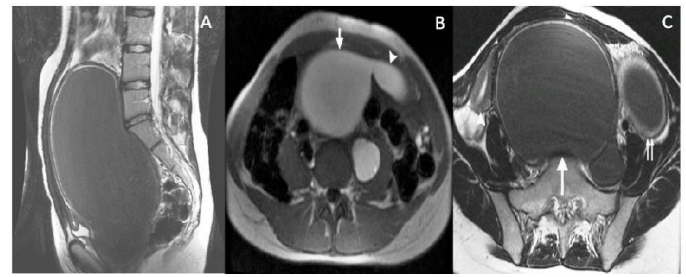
a) Sagittal T₂ weighted MRI, shows a dilated hemivagina with low T₂ - signal-intensity contents and corresponding high T₁ - signal intensity consistent with blood. b) Axial T₁ WI shows left hydrosalpinx containing high T₁ signal intensity contents consistent with blood products, originating from a dilated hemivagina. c) Axial T₁ WI shows a dilated vagina with low T₂ and high T₁ signal intensity contents consistent with blood products, normal appearing right uterine horn and dilated left uterine horn with low T₂ signal intensity blood products.
